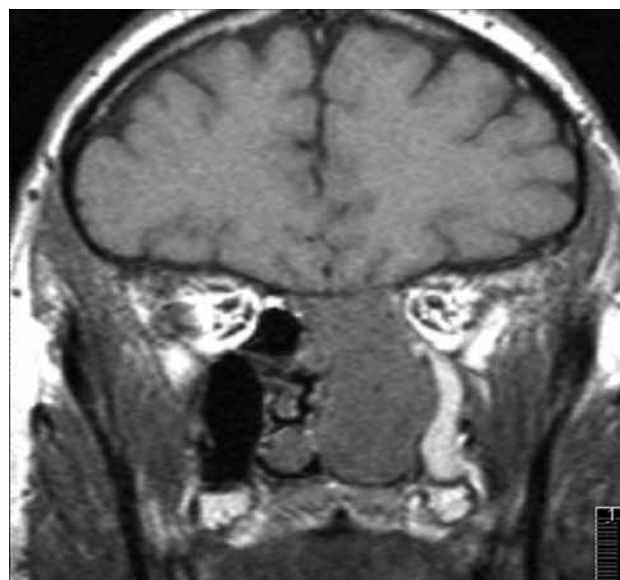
(original): Coronal T1-weighted MRI with gadolinium of olfactory neuroblastoma amenable to endoscopic resection
